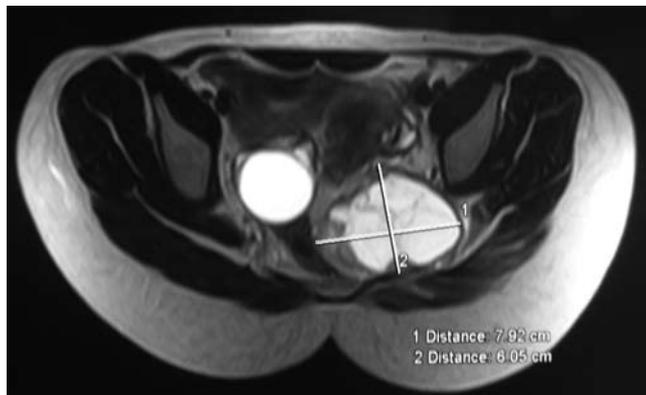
Axial MR image demonstrating sacral tumor and its extent.
